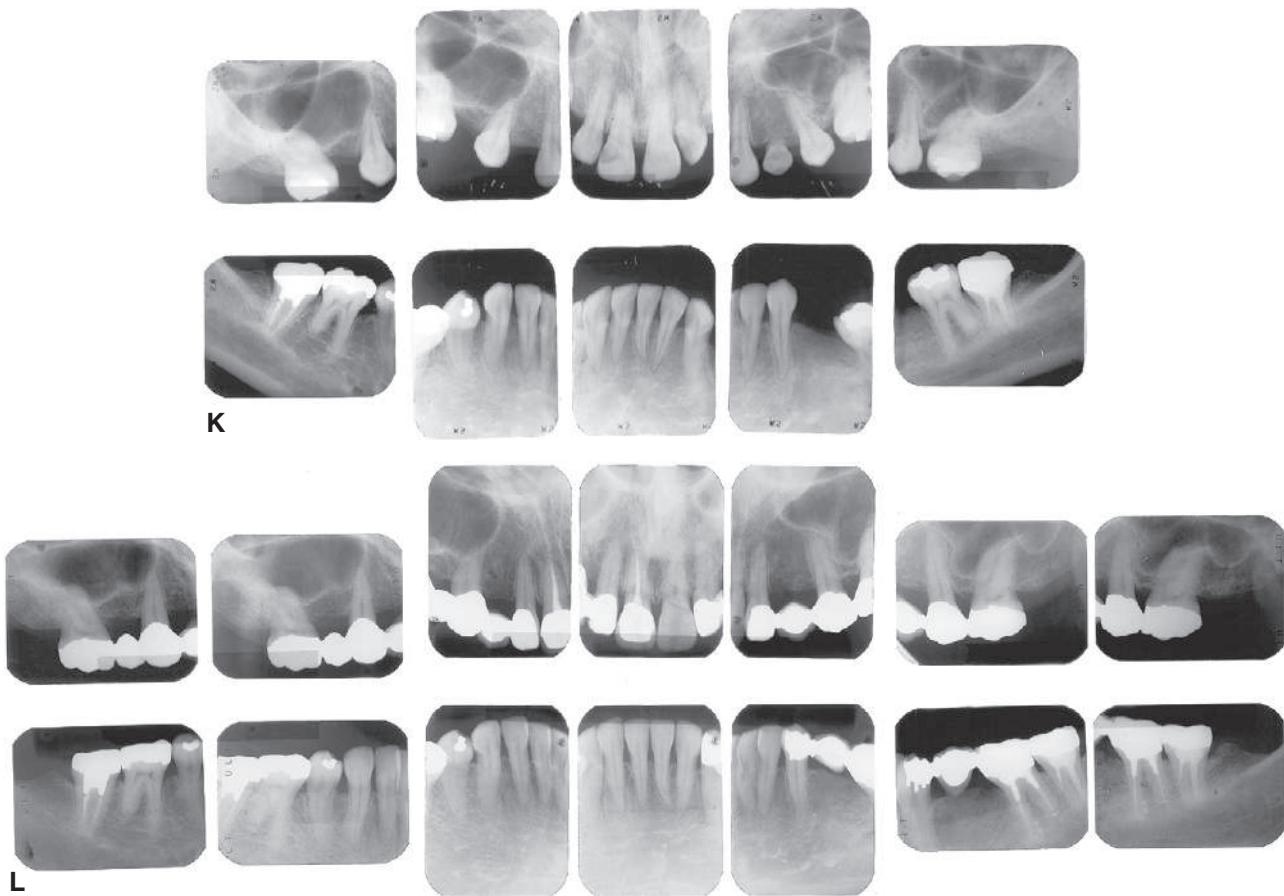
Cont'd (K) Preoperative radiographs. (L) Eighteen-year postoperative radiographs.
